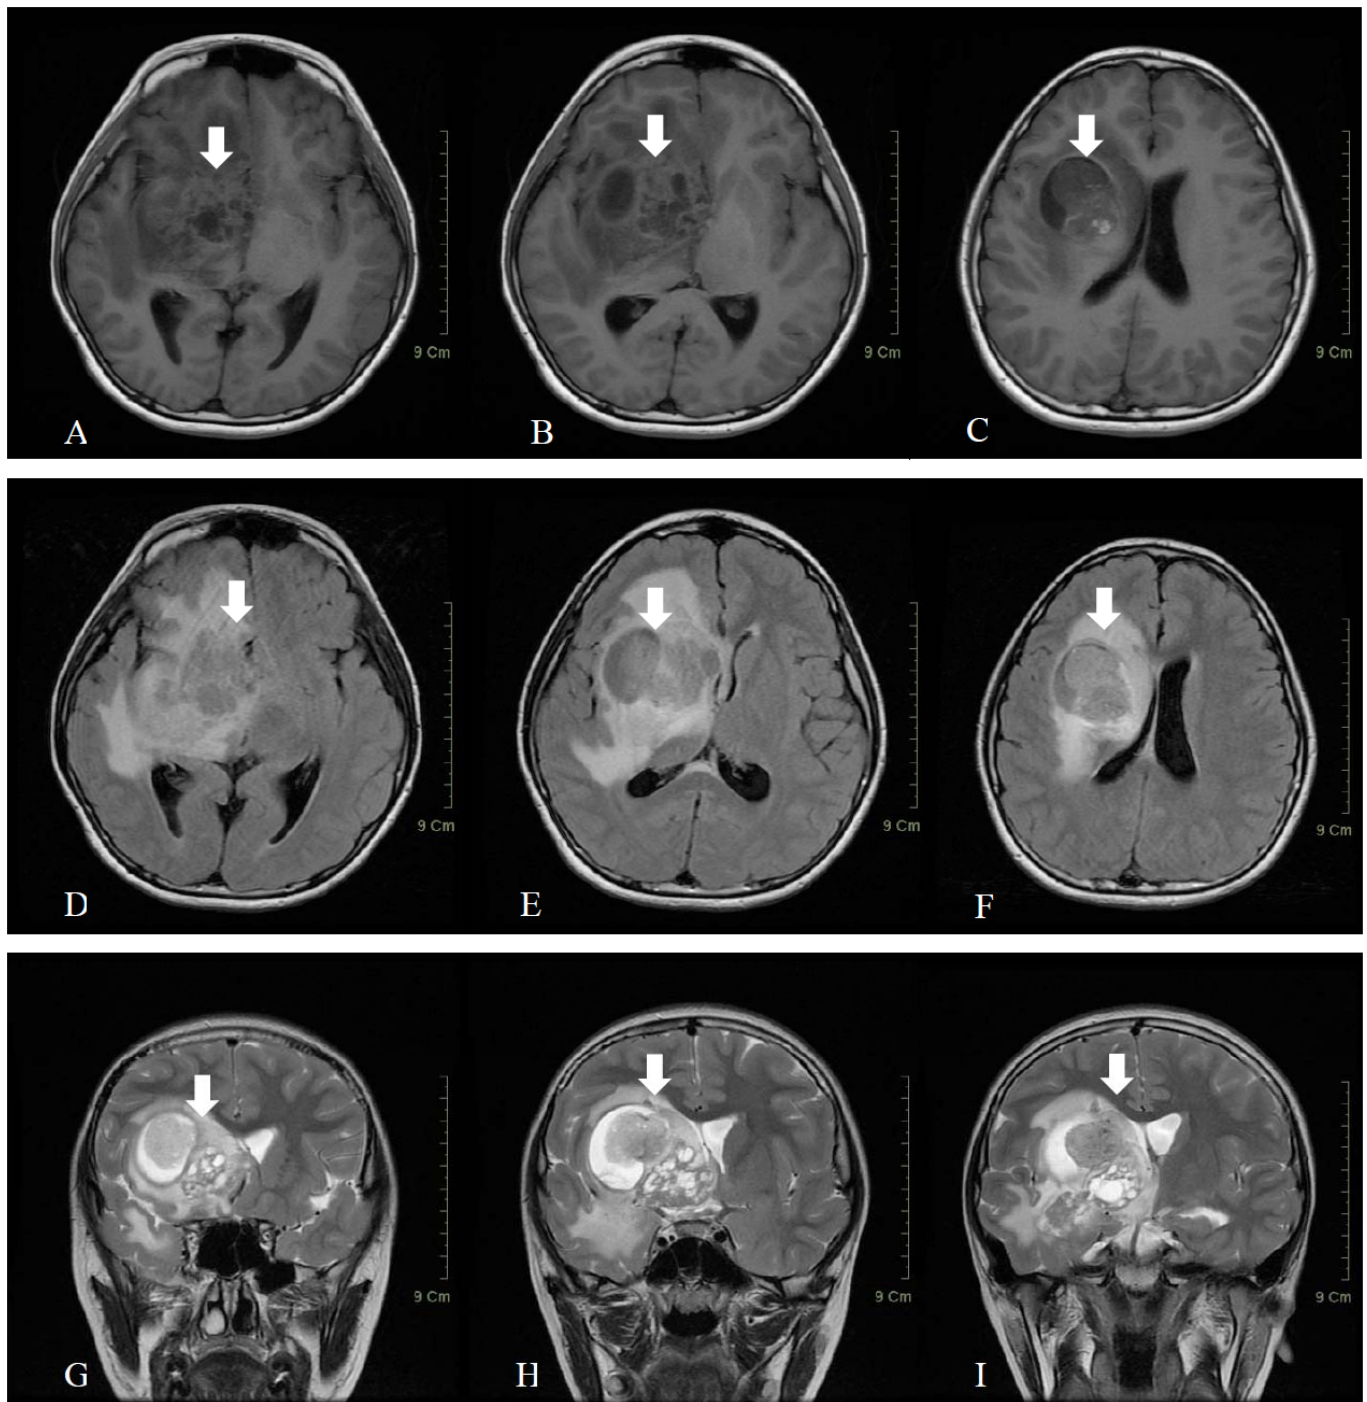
Pre-operation brain MRI images.
